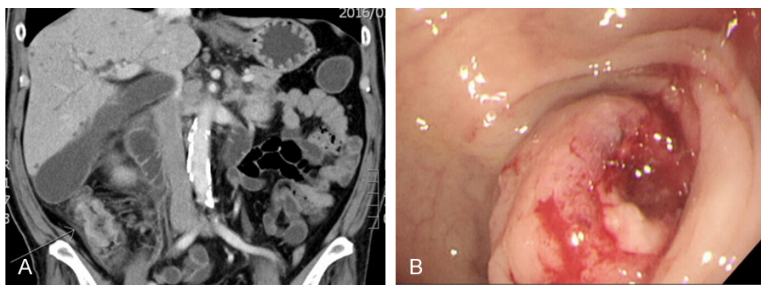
A. Computed tomography revealed a single mass in the ascending colon. B. Endoscopic view of the colonic lesion showing partial obstruction.
